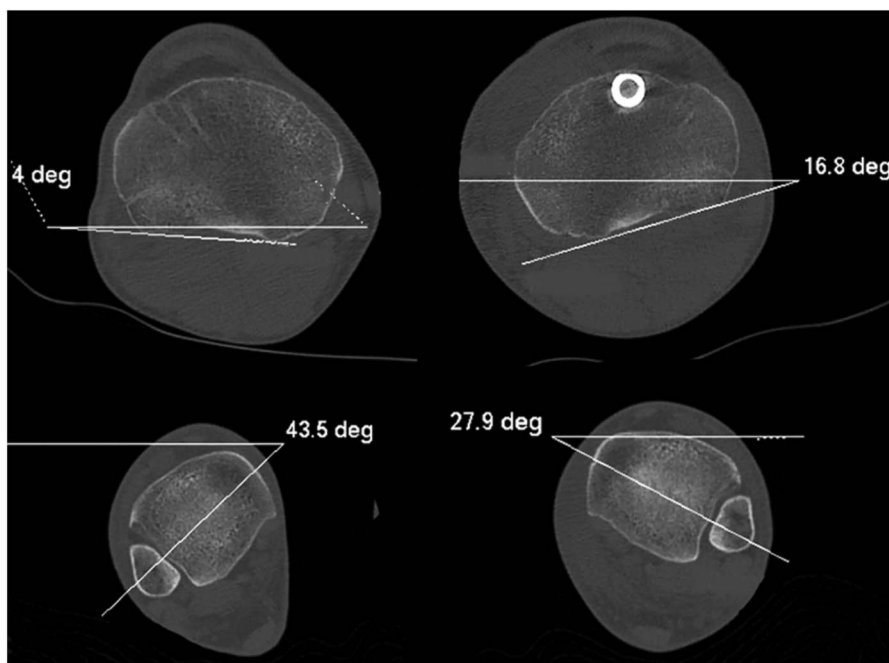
Assessment of postoperative CT slices. The proximal angular measurements are obtained from CT slices 2 to 3 mm proximal to the tibiofibular joint (upper images). The horizontal reference and the line tangential to the dorsal aspect of the tibial plateau determined the angle. The distal angular measurements are obtained 2 to 3 mm proximal to the tibiotalar joint (lower images). To determine the medial point of the distal axis, the first CT slice proximal to the tibiotalar joint displaying the full tibial circumference is used. It is critical that the measurement for the contralateral side is done on the corresponding slice. The angle is determined in the same manner as for the proximal angular measurements. Rotational malalignment is calculated as the difference between the affected ( $27.9^\circ - 16.8^\circ = 44.7^\circ$ ) and unaffected ( $43.5^\circ - 4^\circ = 47.5^\circ$ ) sides, which, in this example, is a rotational malalignment of  $-2.8^\circ$ .
